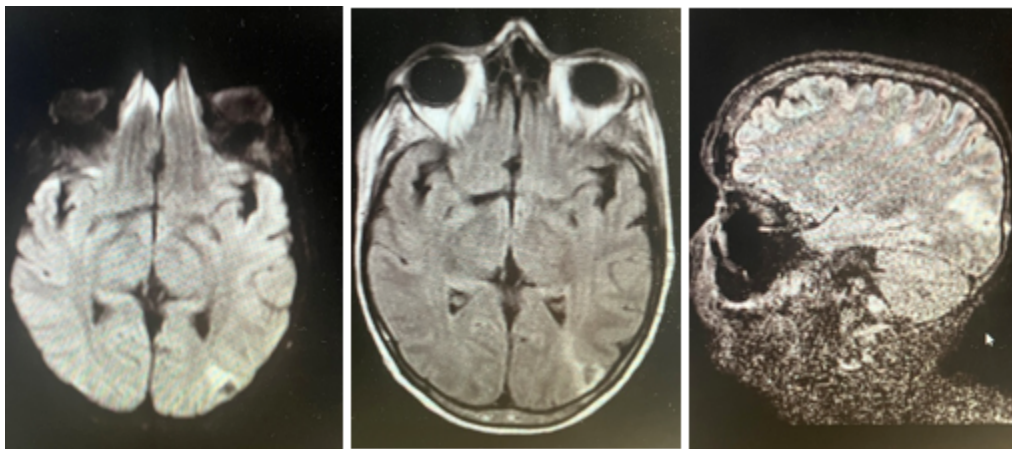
3C: MRI Brain showing Left posterior parietal region hyperintense signal suggesting edema with hemorrhage (3A-Diffusion Weighted image, 3B-Axial T2-FLAIR image & 3C Sagittal FLAIR).
